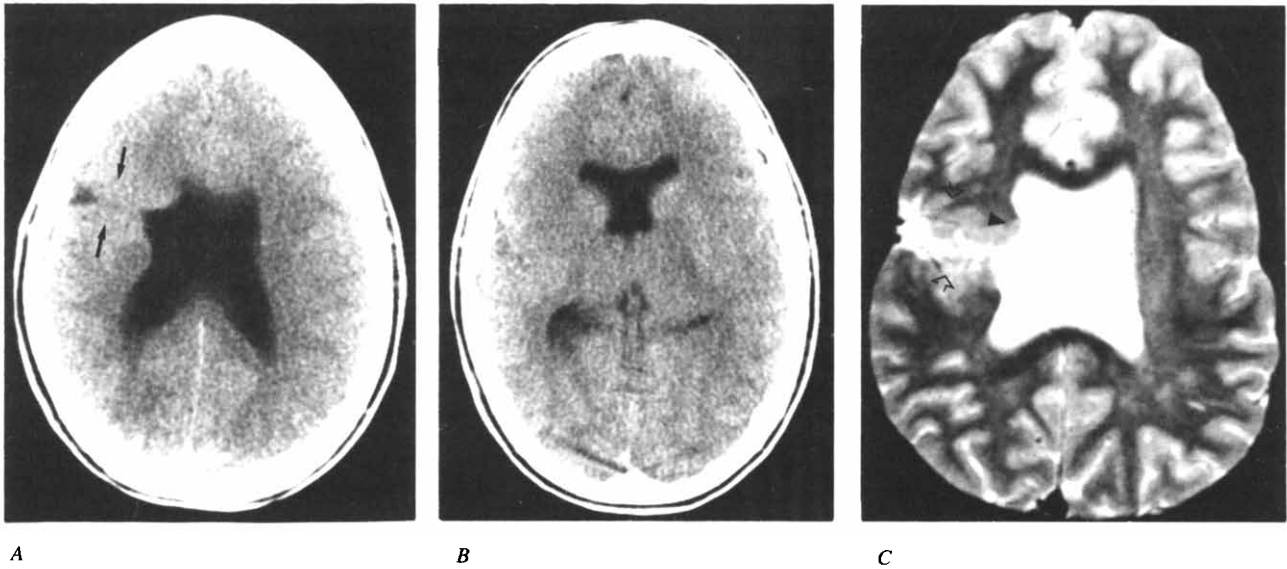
Patient 1. (A) Axial CT at the ventricular bodies reveals a unilateral right-sided schizencephaly of the closed-lip variety. There is subtle high density (gray matter density) that lines the schizencephalic cleft (arrows). (B) Axial CT at the frontal horns reveals an absence of the septum pellucidum. (C) Axial second echo T₂ MRI at the level of the ventricular bodies again discloses the unilateral right-sided schizencephalic cleft which is lined by gray matter intensity (open arrows). An arrowhead has been placed on a focus of heterotopic periventricular gray matter.
